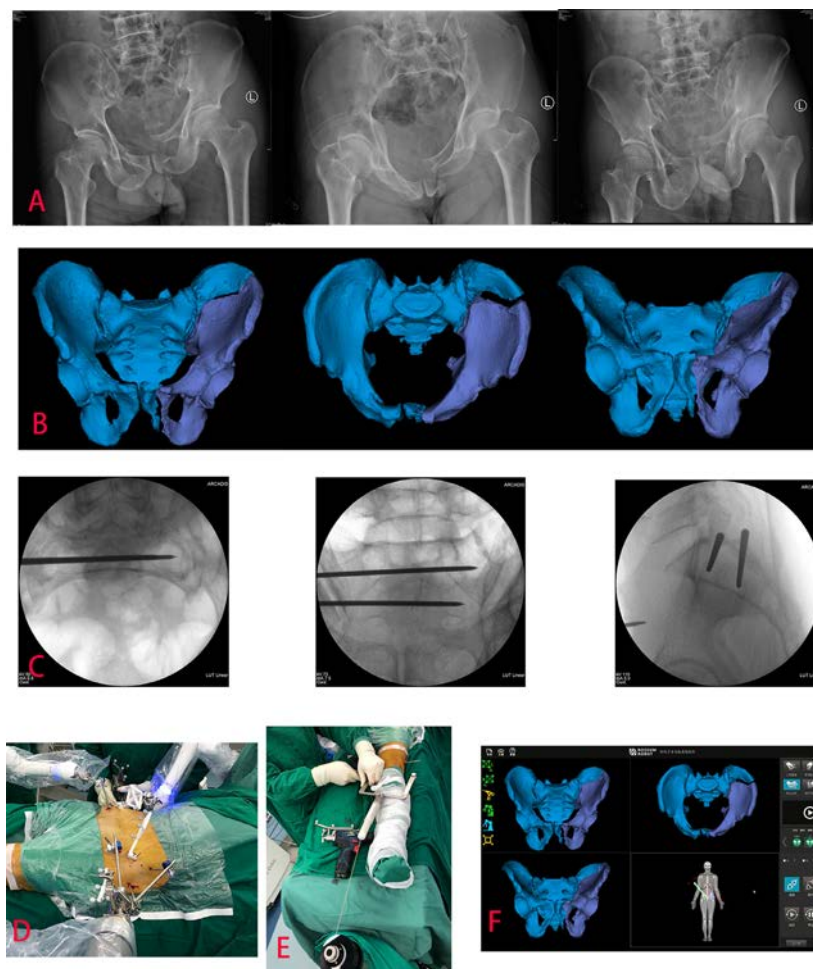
Typical case presentation. A. Preoperative X-ray of unstable pelvic fracture using three standard pelvic radiographic views: anteroposterior, inlet, and outlet views. B. Preoperative path planning of reduction planning. C. The sacroiliac screw guide pin is inserted from the posterior ring of the pelvis on the unaffected side in advance. When the reduction is completed, guide pin can directly penetrate the sacroiliac joint of the affected side, which can assist the temporary fixation of the posterior ring, and can also penetrate the guide pin through the skin of the affected side pelvis to guide the sacroiliac screw fixation of posterior ring. D. All Schantz pins were stably fixed with the end of the mechanical passive arm. E. The bone traction was connected with elastic traction devices. F. After completing image registration, pelvic holding and elastic traction, the position of the pelvic fracture was directly displayed in the monitor.
